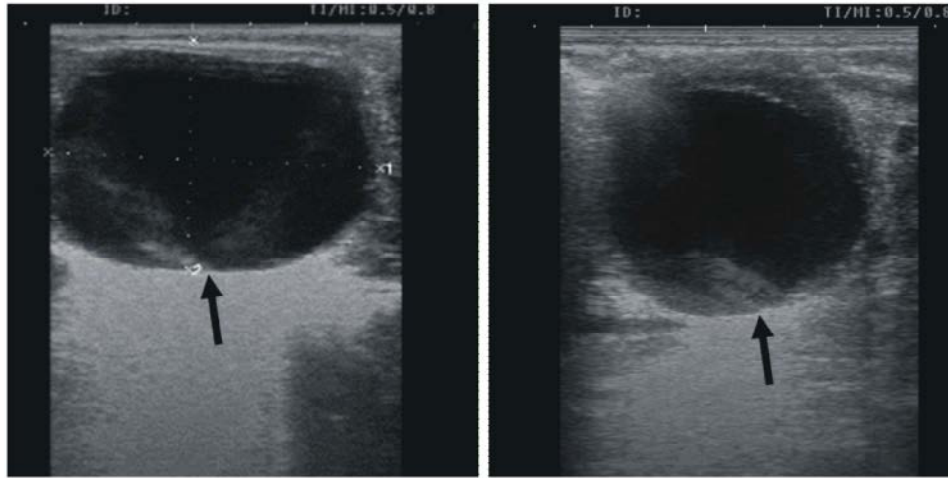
Ultrasonographic characteristics of the ovaries with follicular cyst (black arrows). Follicular cyst > 25 mm in diameter with very thin wall < 3 mm in thickness.
